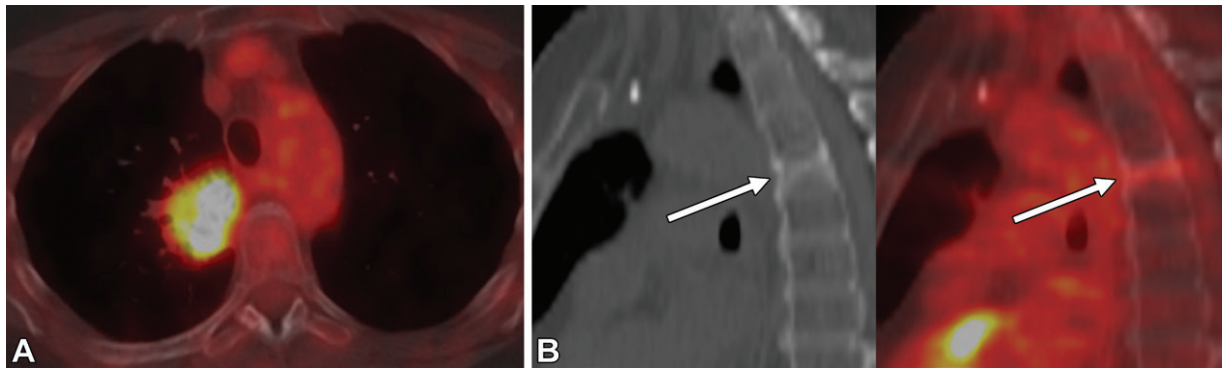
Radiation osteitis with pathologic vertebral compression fracture in a 67-year-old woman with right upper lobe squamous cell carcinoma following chemoradiation therapy. (A) Initial staging fused FDG PET/CT image shows a markedly hypermetabolic mass abutting the pleura adjacent to the T5 vertebral body. (B) At restaging FDG PET/CT performed 9 months after chemoradiation therapy, the right upper lobe lung mass is decreased in size, consistent with treatment response (not shown), although sagittal CT (left) and fused FDG-PET/CT (right) images show that a new T5 compression fracture (arrows) with mildly increased metabolic activity has developed. In addition, decreased uptake in the marrow in the upper to mid thoracic spine is seen at levels above and below the T5 vertebral level within the irradiated field. These findings are most consistent with a subacute to chronic pathologic compression fracture secondary to radiation osteitis, and subsequent surveillance imaging findings confirmed the absence of recurrent disease (not shown).
